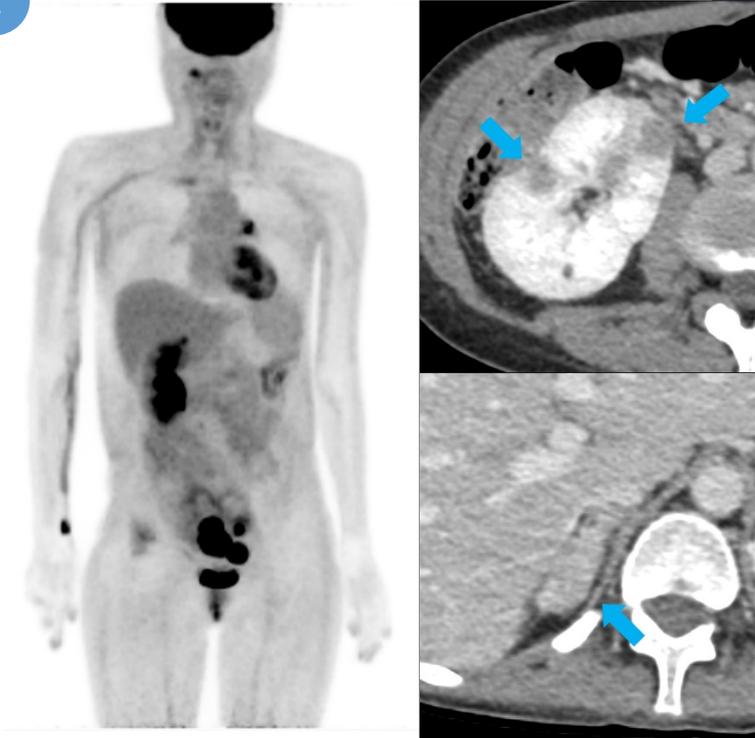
Abdominopelvic CT
